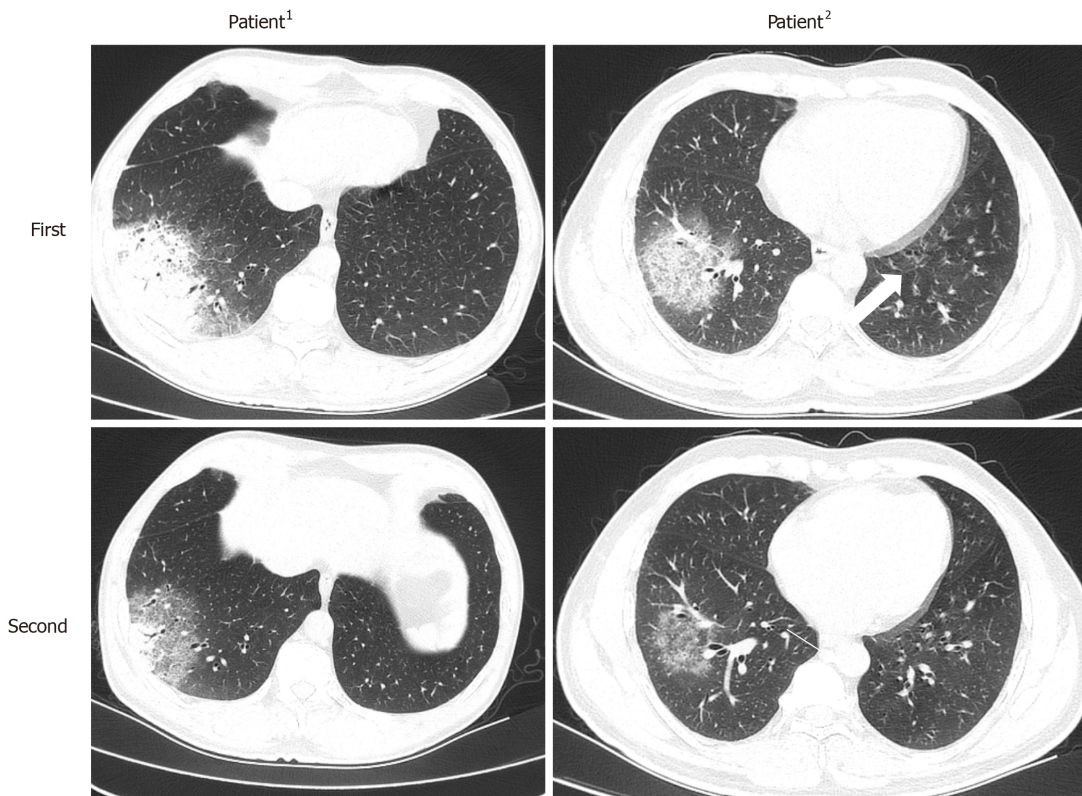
The computed tomography image finding of patients¹⁻² in cluster 2. The patients¹⁻² have similar imaging findings (mixed ground-glass opacity and consolidation) to patients 1-4 and the lesions are absorbed on follow-up computed tomography.
